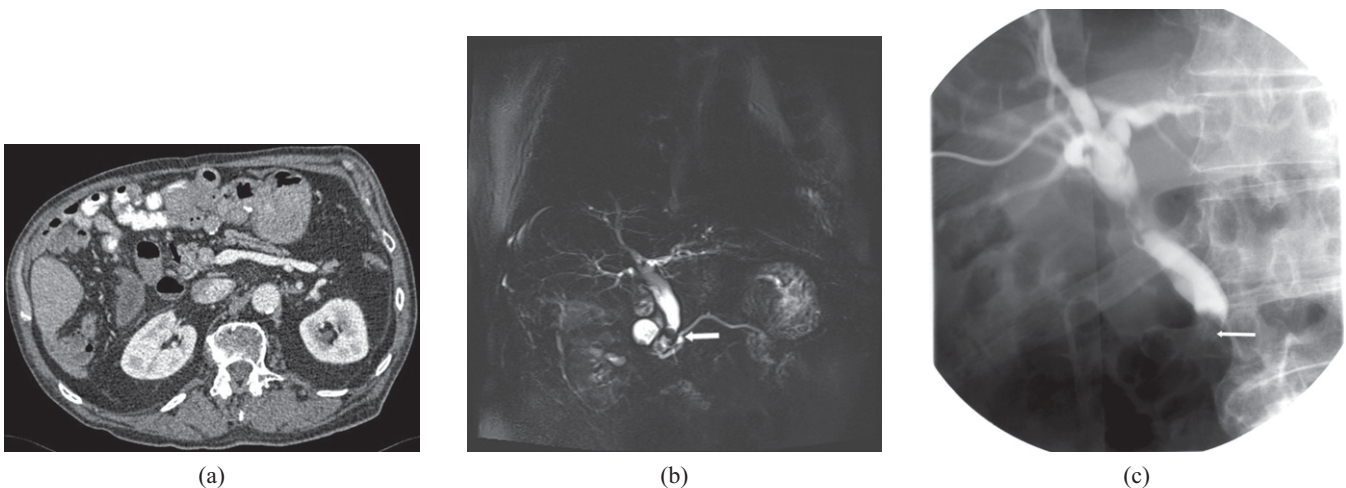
A 75-year-old man with previous history of gastric surgery for peptic ulcer disease presenting with deranged liver function test. Black arrow on axial post-contrast CT scan (a) shows filling defect in the lower common bile duct compatible with a possible obstructing gallstone. Note subtle heterogeneous density at this site on post-contrast scan. Subsequent thin slice coronal magnetic resonance cholangiopancreatography image (b) confirms signal void consistent with a stone in the lower common bile duct (CBD) (white arrow) with upstream dilatation of the CBD and intrahepatic ducts. Because of previous gastrojejunostomy, the patient underwent a percutaneous transhepatic cholangiography to remove the bile duct stone. The white arrow points to filling defect consistent with the stone in the lower CBD (c).
